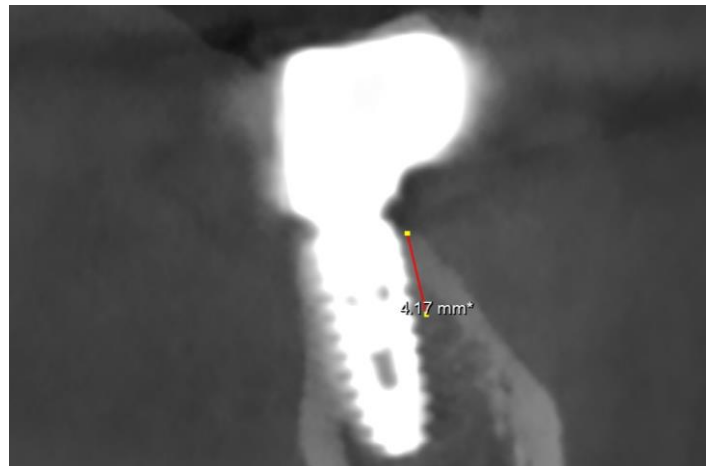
CBCT analysis for measuring MBL
